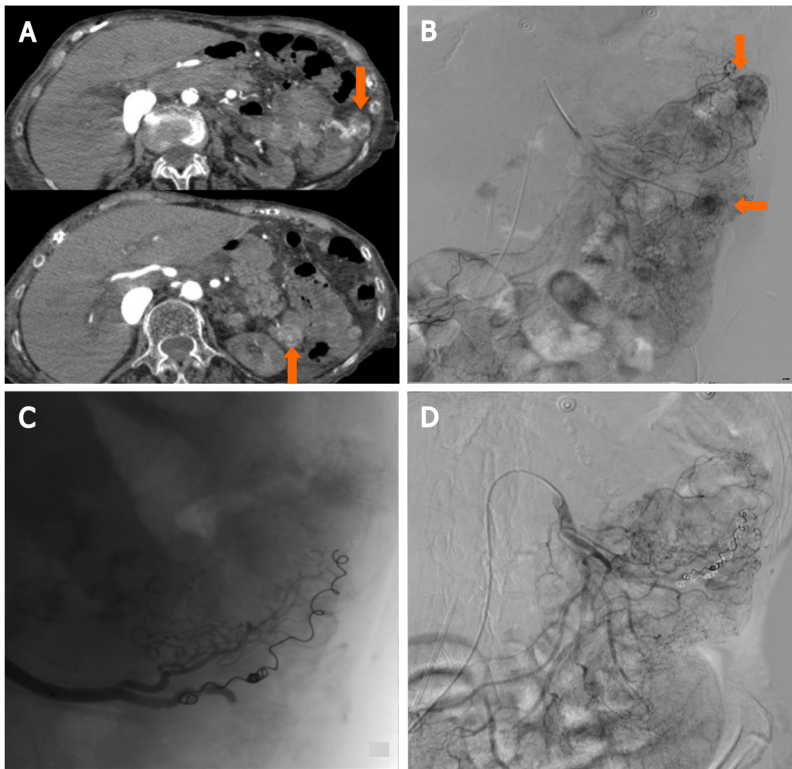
87-year-old female with distal duodenum/proximal jejunum Ca presents with severe recurrent melenas. Endoscopic hemostasis failed in high risk surgical patients with hemodynamic instability and normal coagulation state, requiring embolization after transfusion and hemodynamic stabilization (stabilized blood pressure 90 mmHg with inotropes, HR: 110/min. Hb 6.4). A: Computed tomography-Angio: Two active bleeding sites at proximal jejunum (arrows); B: Selective digital subtraction angiography (DSA) from superior mesenteric artery depicting the bleeding sites (arrows); C: Selective catheterization of the feeding artery with microcatheter and two 3 mm micro coils deployed; D: Lesions are not depicted at final DSA.
